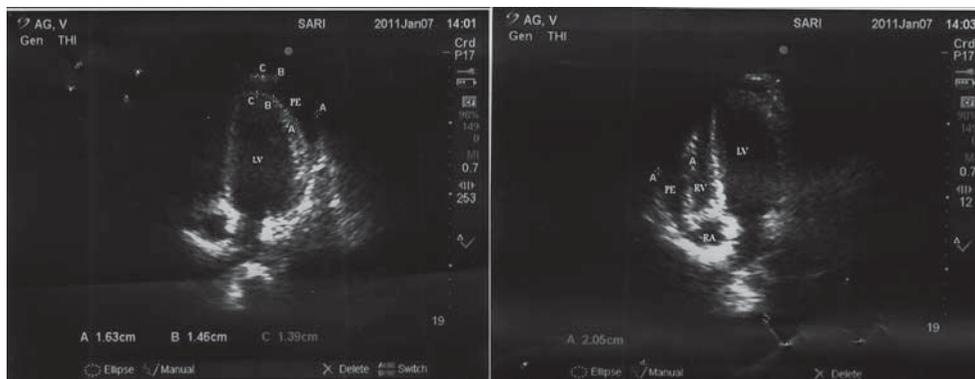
A bedside transthoracic echocardiogram shows left ventricular (LV) enlargement, right ventricle (RV) and right atrium (RA) diastolic collapse, and moderate to large pericardial effusion (PE) on both sides.
